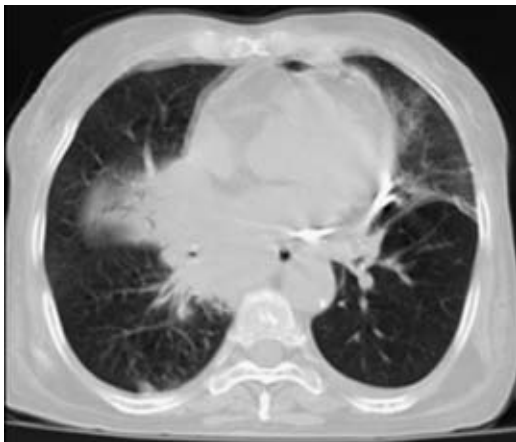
Thoracic CT-scan: numerous mediastinic lymphadenopathies causing compression of the medial esophagus and of the main right bronchus
